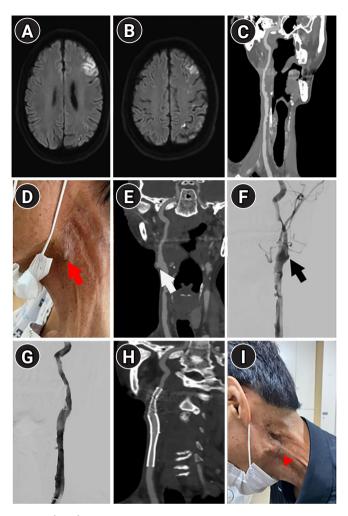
(A, B) Cortical and border-zone infarctions in the left cerebral hemisphere. (C) Multifocal long-segment stenosis of the left common carotid artery extending to the proximal internal carotid artery on computed tomography angiography. (D) A pulsating mass in the vicinity of the previous injury site of the carotid artery (red arrow). (E) Pseudoaneurysm immediately beneath the skin (white arrow). (F) Pseudoaneurysm (black arrow) with long-segment stenosis of the left common carotid artery on digital subtraction angiogram. (G) Non-visualization of pseudoaneurysm after deployment of a self-expandable stent graft. (H) The disappearance of the pseudoaneurysm with good stent patency on computed tomography angiogram 7 days after endovascular treatment. (I) The disappearance of the pulsatile mass in the vicinity of the previous injury site of the carotid artery (red arrowhead) after 3 months.
